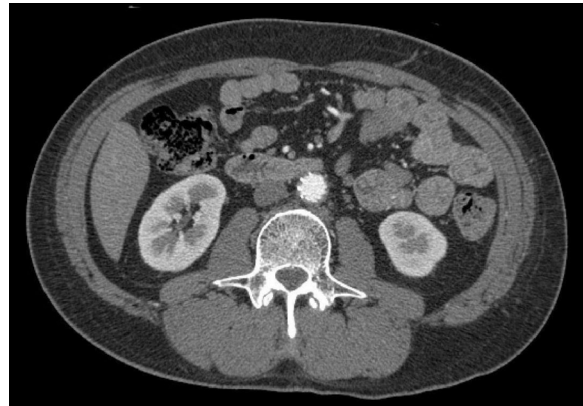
The 3-month follow-up computed tomography (CT) scan with stable configuration of stent graft and resolution of surrounding hematoma.
